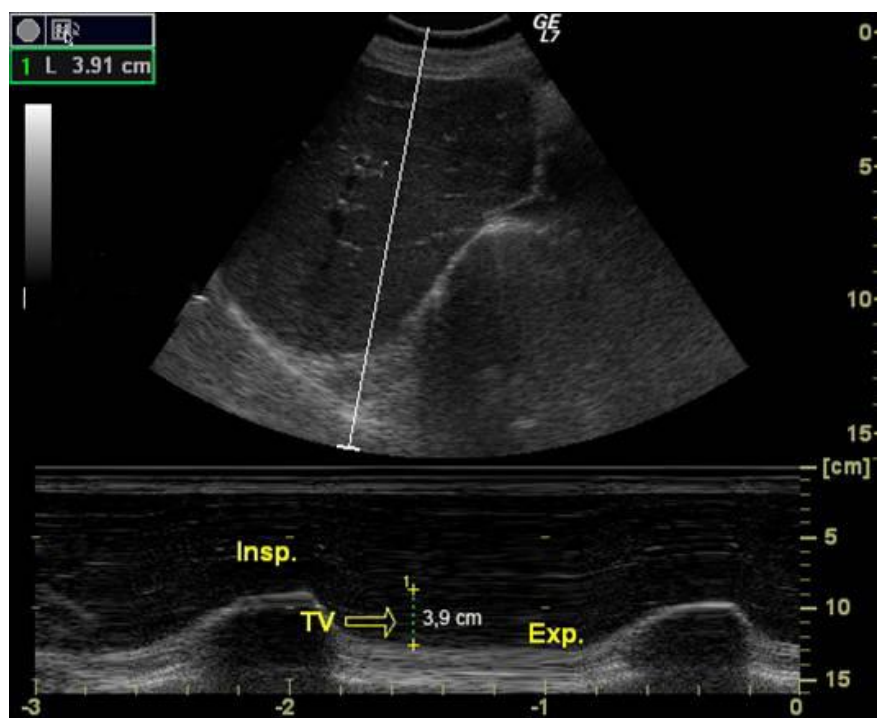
Measuring the diaphragmatic function by M - mod ultrasonography
